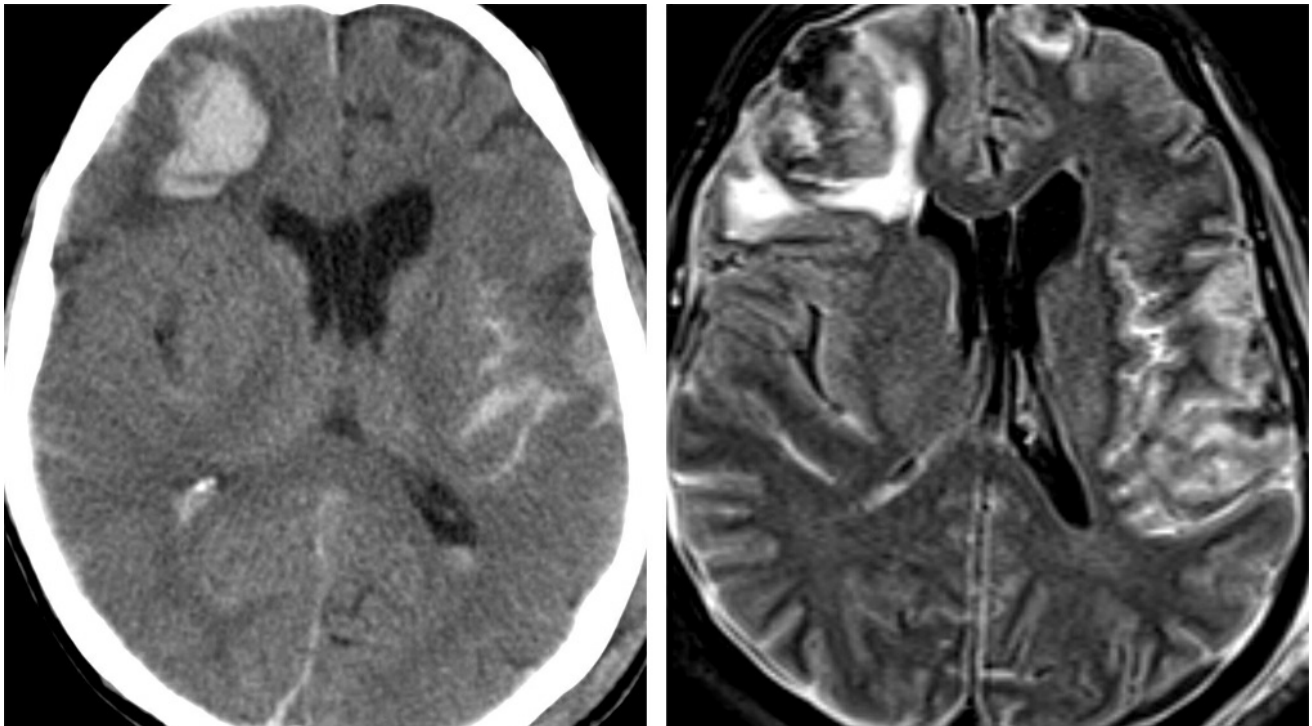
CT (left) and FLAIR MRI (right) images demonstrate a number of findings in this post-traumatic patient. Subarachnoid blood in the sulci is most pronounced in the left Sylvian fissure as dense on CT and hyperintense on FLAIR. In fact, the FLAIR is often more sensitive for detection of subarachnoid hemorrhage unless in the basal cisterns. Intraventricular blood is also present. The CT-hyperdense, FLAIR-heterogeneous hematoma in the right frontal lobe represents a hemorrhagic contusion. The surrounding edema is hypodense on CT and hyperintense on FLAIR, as expected. Thin subdural hematomas are more
